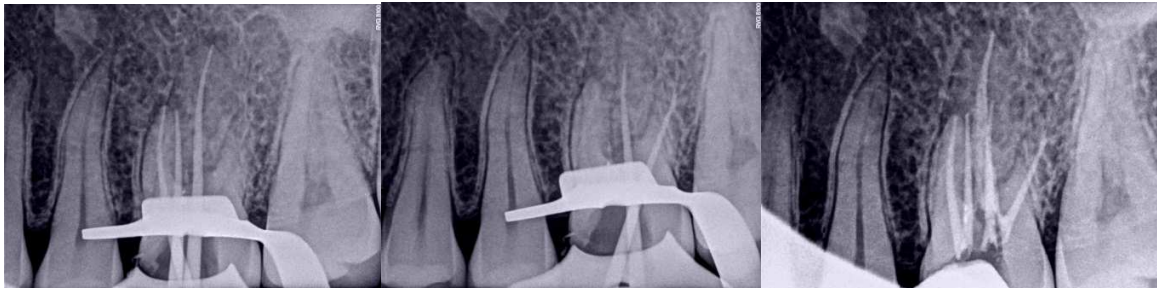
The master cones Radiograph for Mesial and palatal canals
